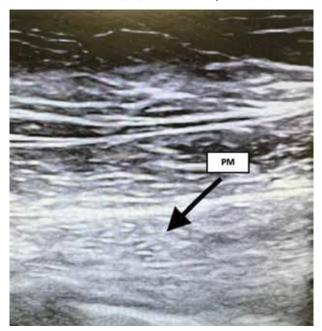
Sonographic view of the pectoralis minor muscle (PM).
